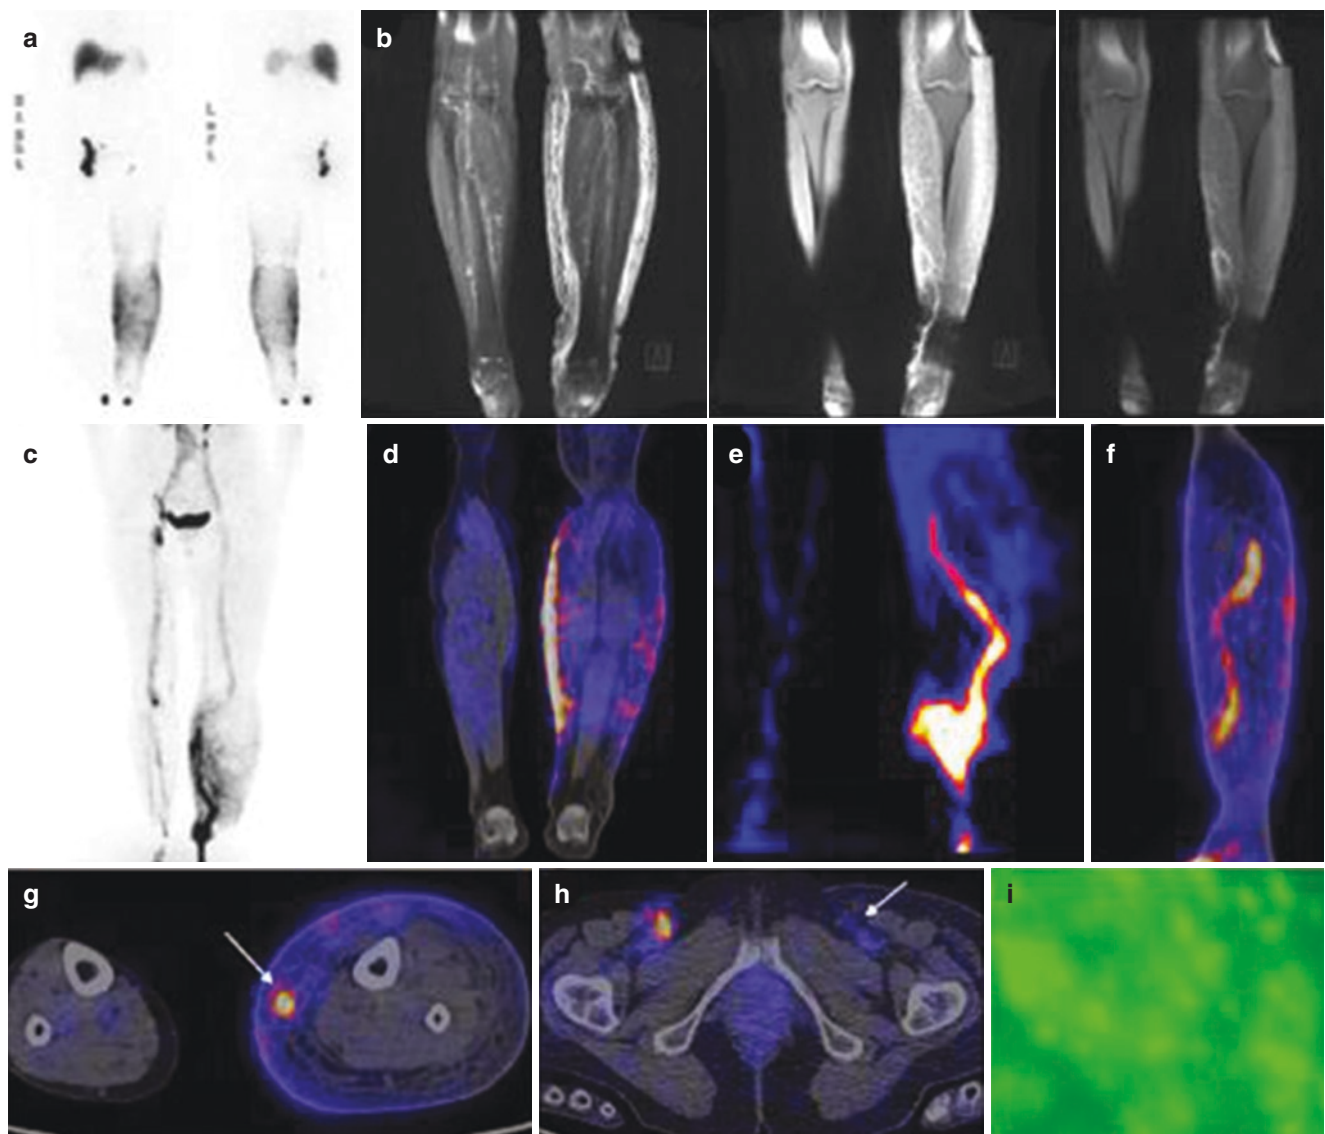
(a) Lymphoscintigraphy with ^{99m}Tc -sulfur colloid obtained in a patient with severe edema of the left lower limb shows large and diffuse dermal backflow of the left lower limb, associated with absent tracer accumulation in left inguinal lymph nodes. (b) In the same patient, MR lymphangiography shows increased subcutaneous thickness and diffuse fibrosis of the left leg, as well as dilated and tortuous deep-seated lymphatic channels of the left medial calf (coronal images). PET/CT was acquired 60 min after interstitial injection of ^{68}Ga -NEB. The MIP image displayed in (c) shows severe and diffuse dermal backflow of the left leg, associated with reduced/absent tracer
